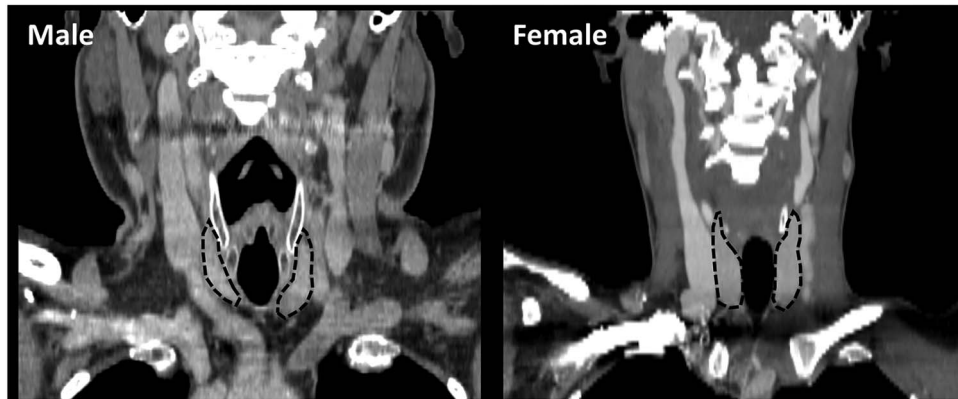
Coronal views of the neck CT scans for adult male (left) and female (right) patients with the thyroid contours marked by dashed lines. This comparison demonstrates a generalized example of anatomic variability of the thyroid.
